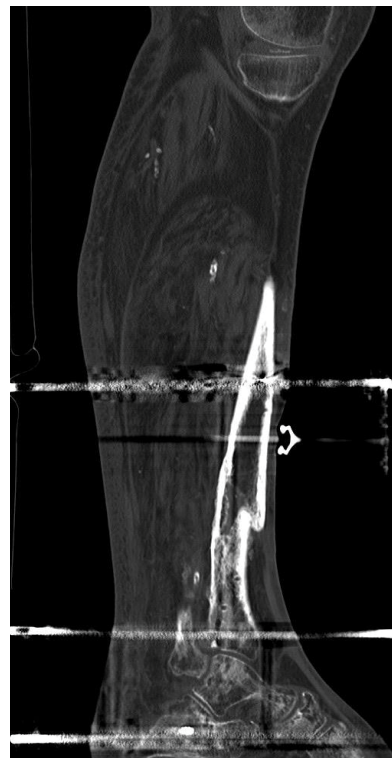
Six weeks postoperative AP radiograph.
